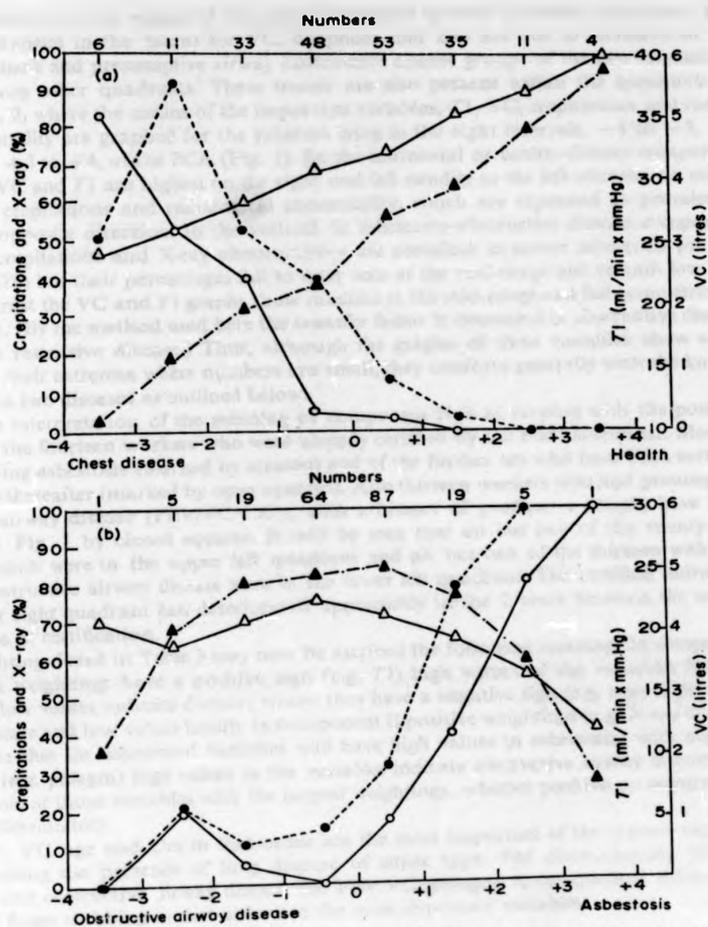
Unadjusted means of the transfer factor (Tl) (Δ), vital capacity (VC) (\triangle), and the prevalence of X-ray abnormality (\bullet) and crepitations (\circ) for subjects lying within (a) the horizontal intervals (component I) of the PCA (Fig. 1), and (b) the vertical intervals (component II) of the PCA (Fig. 1).
